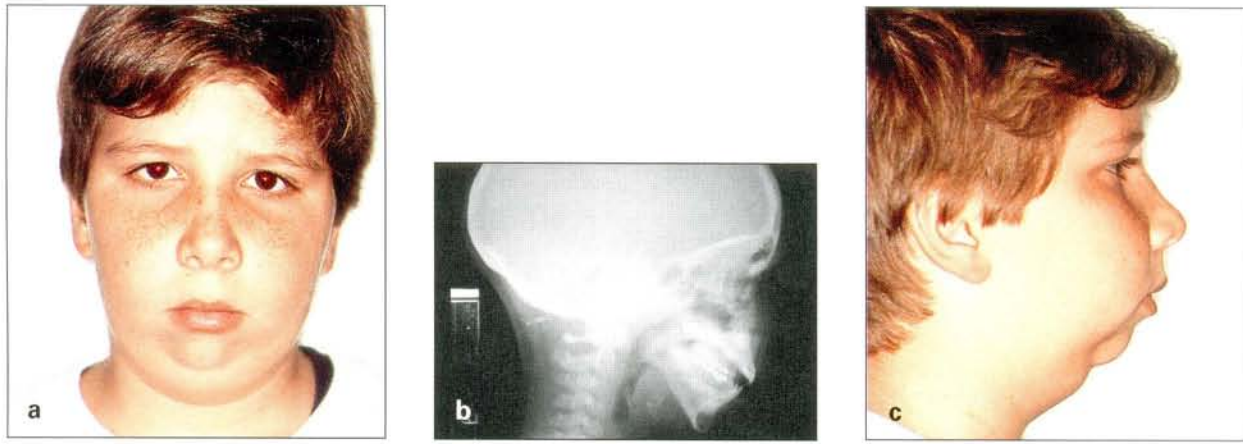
July 24, 1991 (age 13 years, 2 months): (a) Frontal view. (b) Radiograph. (c) Profile view.
